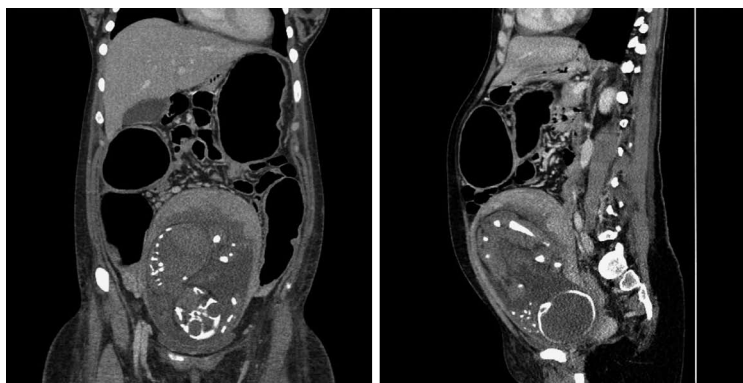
Abdominal computed tomography scan showing toxic megacolon during pregnancy. Ascending colon diameter was 7.6 cm, transverse colon 9.2 cm, and descending colon 5.7 cm, which was consistent with toxic megacolon. Bowel wall thickness is normal without signs of ischemic sufferance. No abdominal free gas or effusion.
